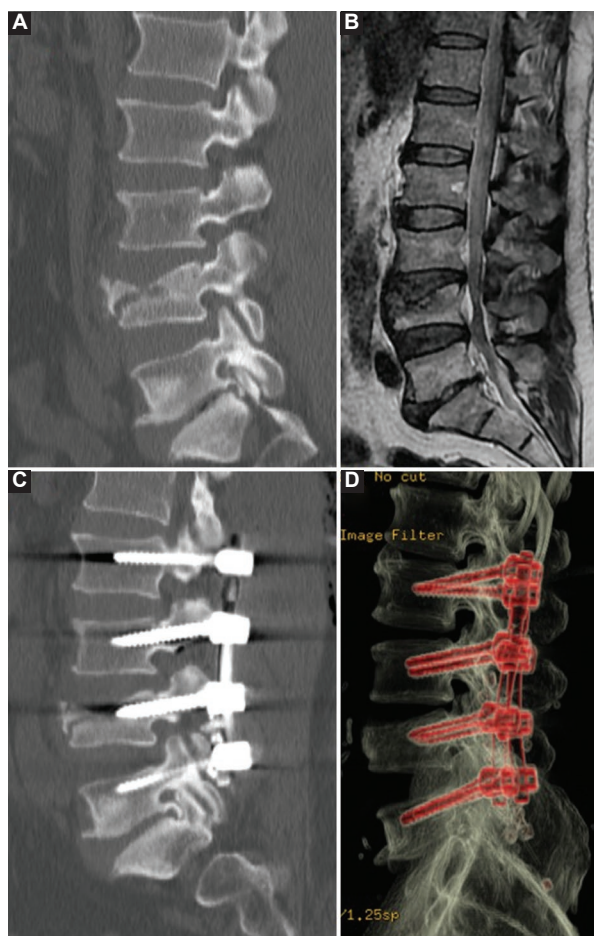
Radiological image. A and B: pre-operative magnetic resonance imaging image. C: post-operative MRI image, D: post-operative 3D computed tomography image.
